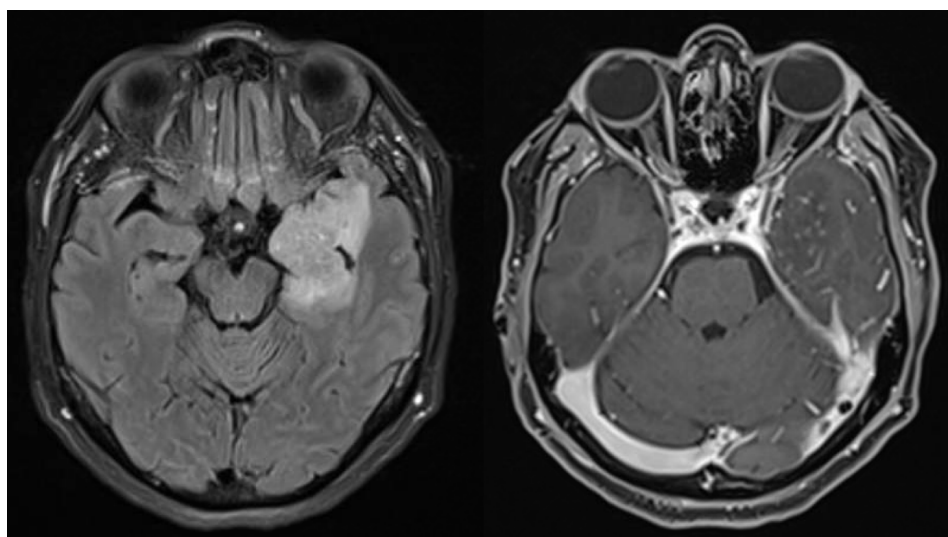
FLAIR and Gadolinium-enhanced t1 sequences from initial MRI.
